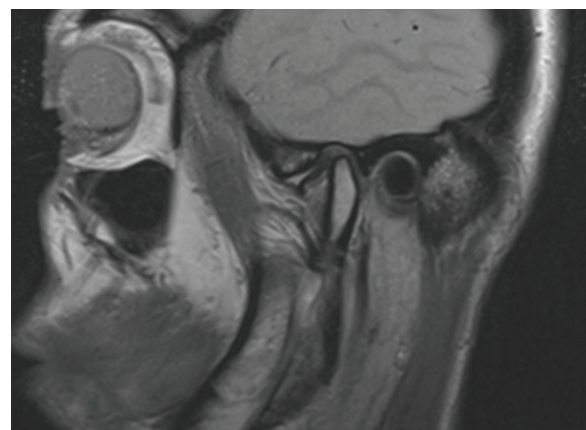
The MRI examination revealed effusion in the upper joint space, with the anterior disc positioned in the closed-mouth position and appearing normal in shape.
